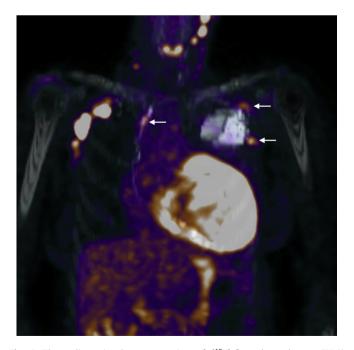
Three dimensional reconstruction of [¹⁸F]-fluorodeoxyglucose (FDG) positron emission tomography-computed tomography images showing an increased uptake of FDG in the superior vena cava portion of the implantable cardioverter-defibrillator (ICD) lead and on 2 portions of the ICD generator (white arrows).
